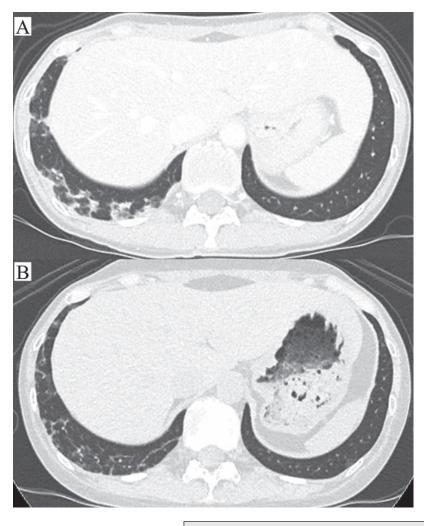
Chest computed tomography showing groundglass opacity and consolidation at the right lung field bottom region (A) before treatment and (B) improved lesions after treatment.
